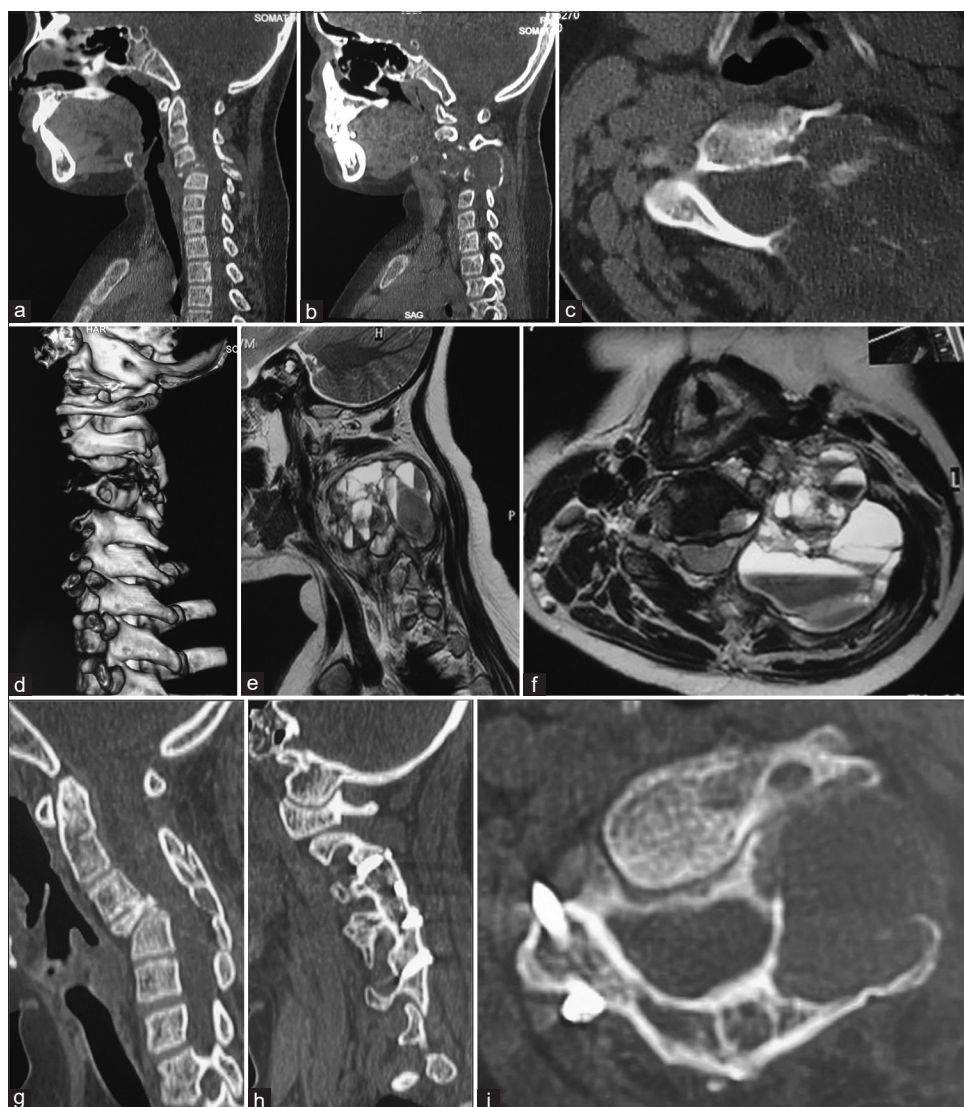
Images of a 7-year-old female child. (a) Sagittal CT scan of the cervical spine showing the destruction of the C4 vertebral body and listhesis of C3 over the C4 vertebra, (b) Sagittal cut of CT scan through the facets showing the expansile and lytic tumor involving and destroying the left side C3, C4, and C5 facets and pedicles, (c) Axial image (at C3 spinal level) showing the tumor and destruction of the lamina, pedicle, transverse process and part of the vertebral body, (d) 3D reconstructed image of CT scan showing the unilateral destruction of the C3–C5 facets, (e) T2-weighted sagittal MRI image showing the expansile lesion with multiple cysts, each having fluid-fluid levels, (f) T2 weighted axial image showing the tumor, (g) Sagittal CT scan after 24 months of surgery showing bone fusion of posterior elements of C2–C6 spinal segments, (h) Sagittal CT scans with the cuts passing through the facets showing C2-6 facet fusion, (i) Axial CT scan showing the tumor in the paraspinous region. Transarticular screw can be seen. CT - Computed tomography, MRI - Magnetic resonance imaging
